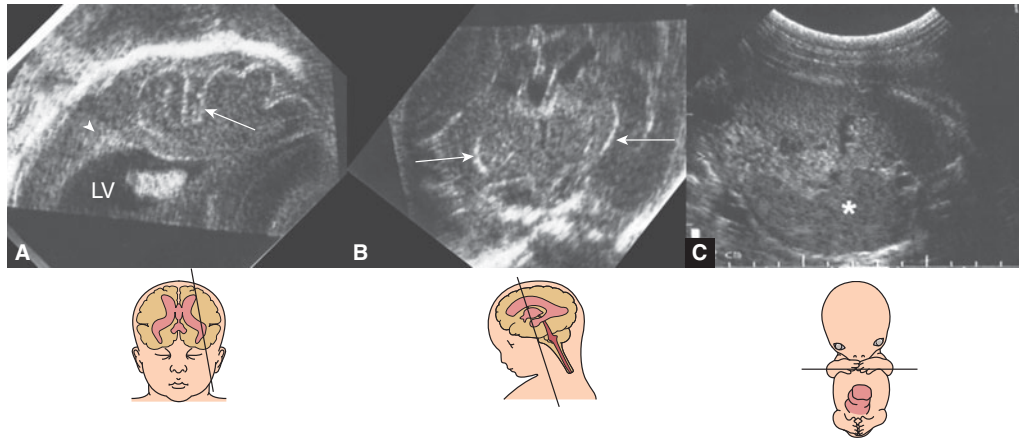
Ultrasonographic appearance of the fetal brain and spleen in a patient with congenital syphilis at 34 postmenstrual weeks. (A) Parasagittal transvaginal sonography (TVS) section at the level of the lateral ventricle (*) shows pachygyria (arrow) and abnormal periventricular echogenicity (arrowhead). (B) Coronal TVS section at the level of the thalami shows striatal vasculopathy (arrows). (C) Splenomegaly (*).
